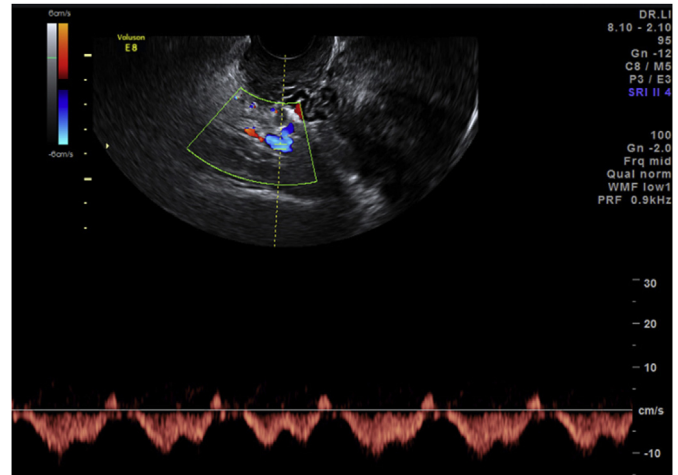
Sonography using color Doppler reveals residual trophoblastic flows with a bizarre pattern.
